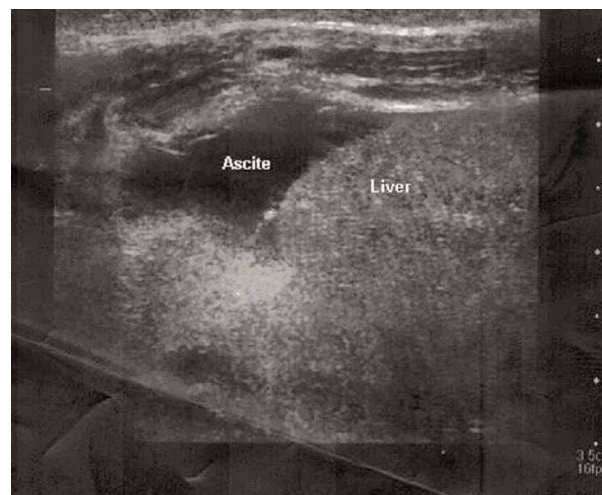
Postnatal abdominal ultrasound image showing ascites.
